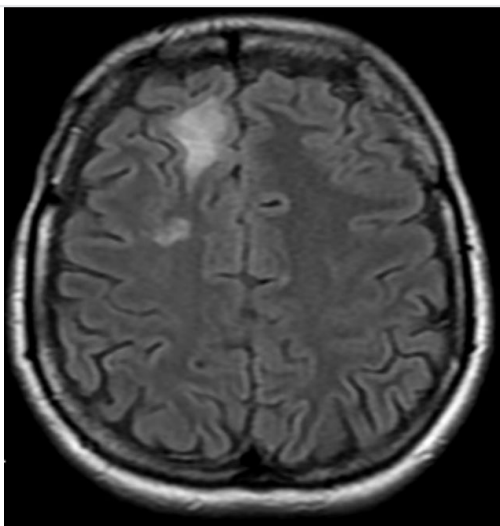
Pre-operative axial T1 weighted FLAIR magnetic resonance image
